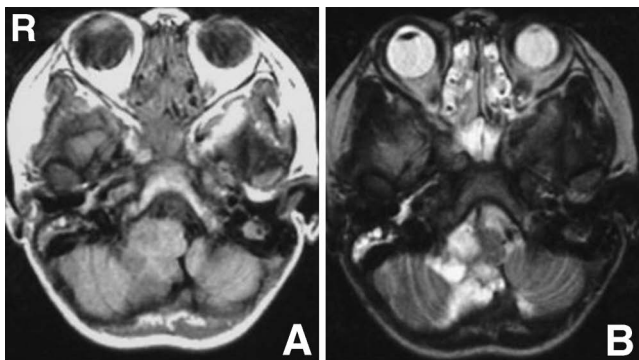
Neuroimaging findings at age 7 years. Axial T₁-weighted (A) and T₂-weighted (B) magnetic resonance images showing a cystic tumor with no apparent tumor progression.
